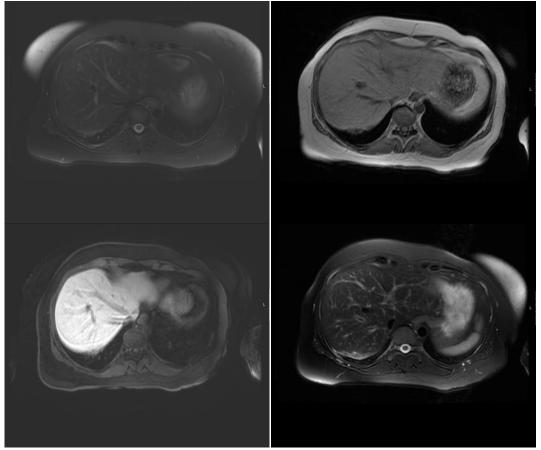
MRI liver and inferior thorax (axial sequences) at 3 months post embolisation.
